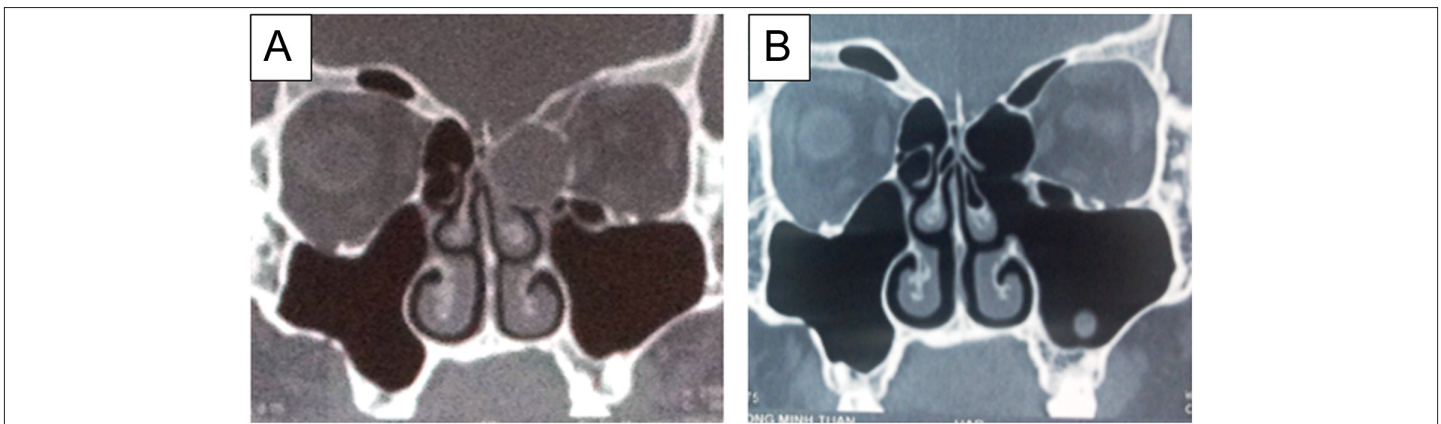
Computed tomography of patient before and after Endoscopic Sinus Surgery (ESS). A. Before ESS, B. after ESS.
